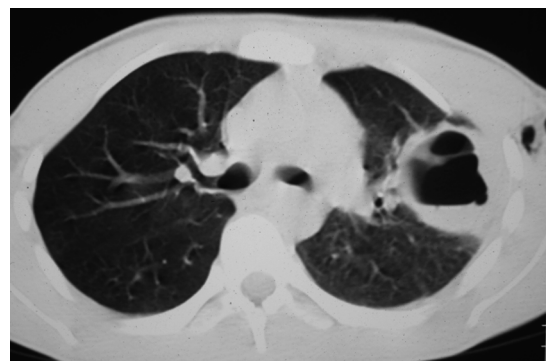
Computed tomogram shows a post-traumatic pulmonary pseudocyst.
